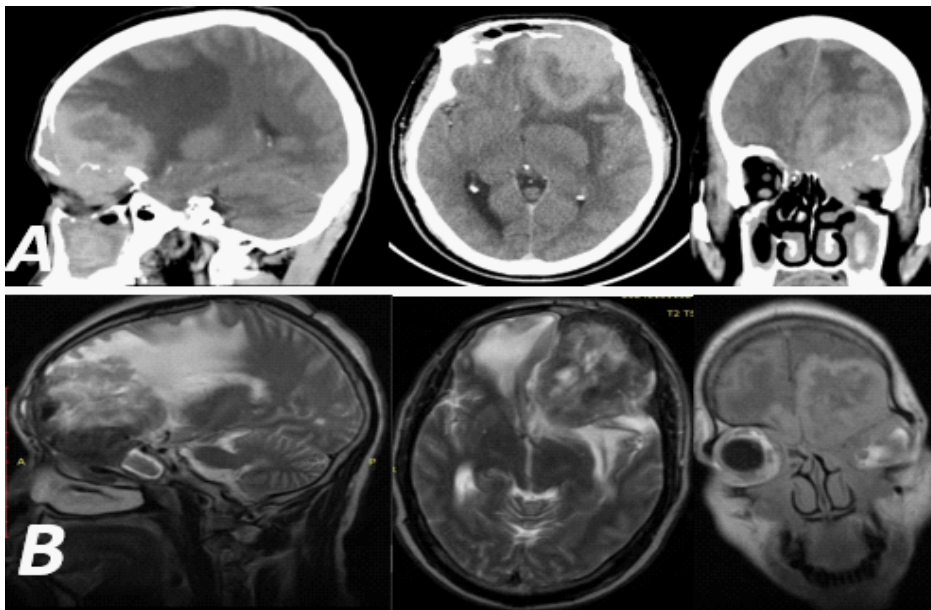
(a) Brain CT scan of left sub-frontal mass extending into the sphenoid sinus with necrotic core and calcifications, eroding the roof of the orbit and invading the left maxillary sinus and (b) Brain MRI showing a huge left mixed intensity rhino-orbito-sub frontal mass invading and displacing the frontal lobe superiorly with necrotic core, extending into the sphenoid sinus and left maxillary sinus and complete destruction of the orbital roof.
